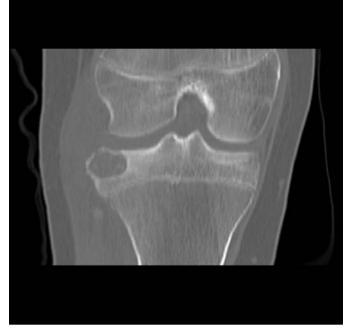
CT scan showing a well-circumscribed lesion in the epiphysis of a skeletally immature patient. There are flecks of calcification within the lesion which is classic in position and appearance of a chondroblastoma
